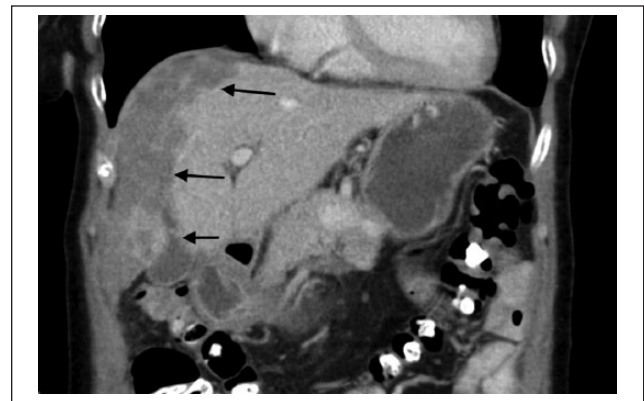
Computed tomography scan of December 1, 2014: Mild hepatomegaly, resolvable malignant zone.
